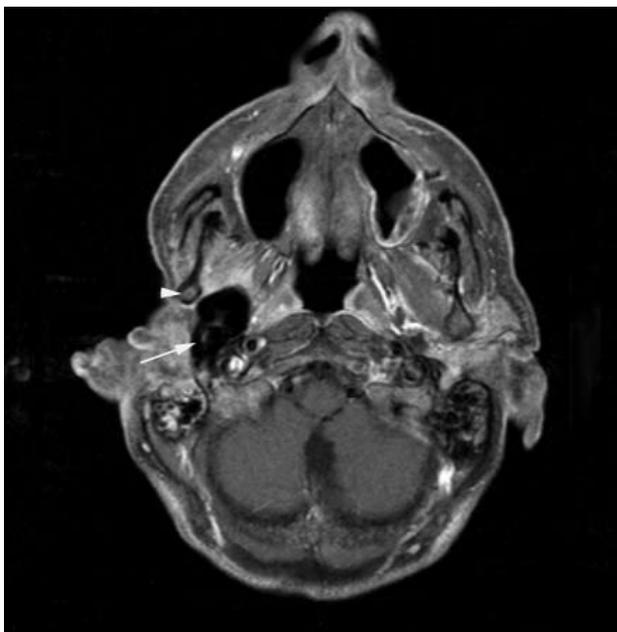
Contrast-enhanced axial magnetic resonance image obtained after resection of the parotid tumor in the patient in case 1. During surgery, the tumor had infiltrated the temporomandibular joint but apparently not yet the mandible. This postsurgical image indicates an anteriorly displaced mandibular condyle (arrowhead) and a dead space (arrow) in the region of the temporomandibular joint.
